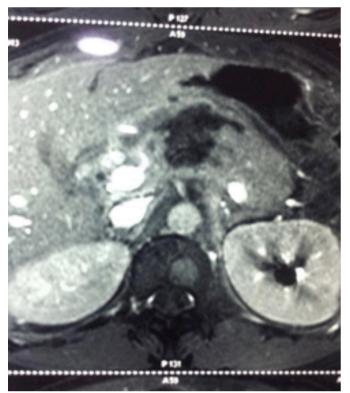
Contrast-enhanced CT scan showing pancreatic injury.
